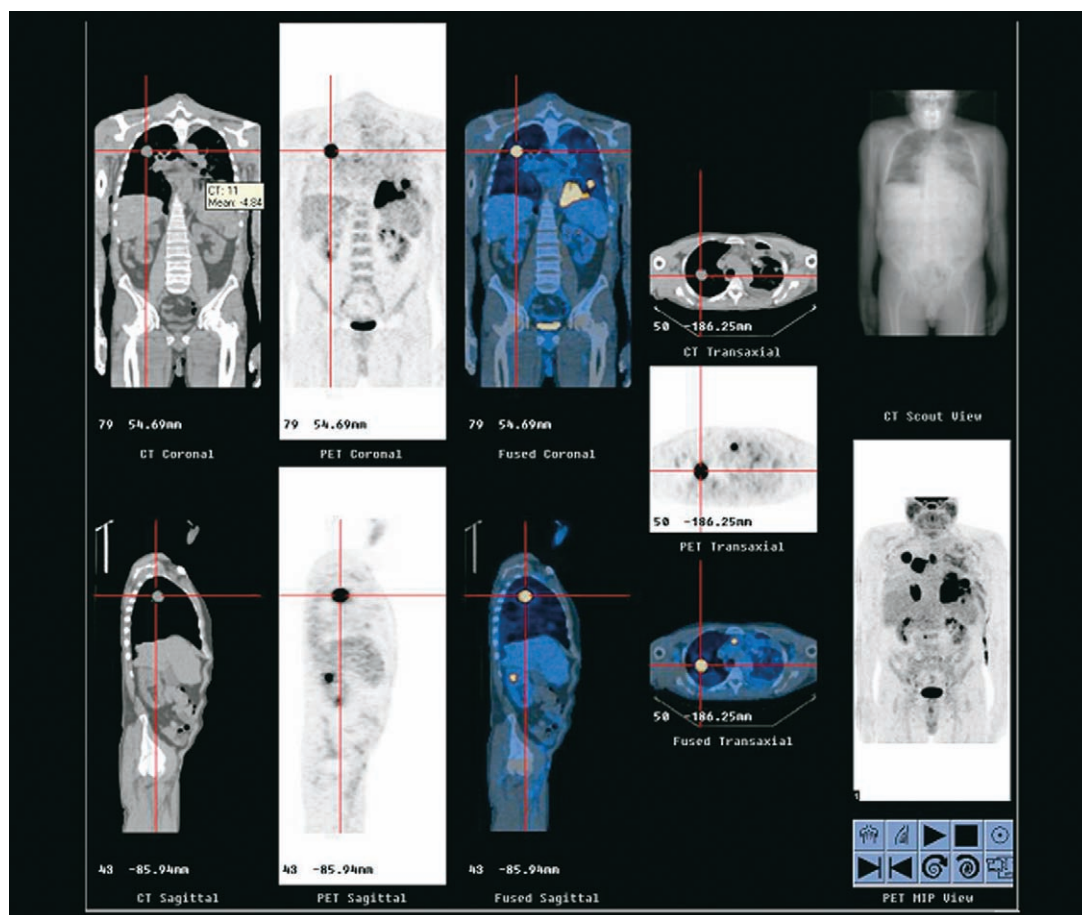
$^{18}\text{F}$ FDG-PET, CT, and fusion images from a 50-year-old HIV+ man demonstrating a hypermetabolic mass in the right lung and mediastinal lymphadenopathy and infradiaphragmatic disease. Diagnosis: non-Hodgkin's lymphoma. (Courtesy of Division of Nuclear Medicine, Department of Radiology, New York Presbyterian Hospital, Weill Cornell Medical Center, New York, NY).
